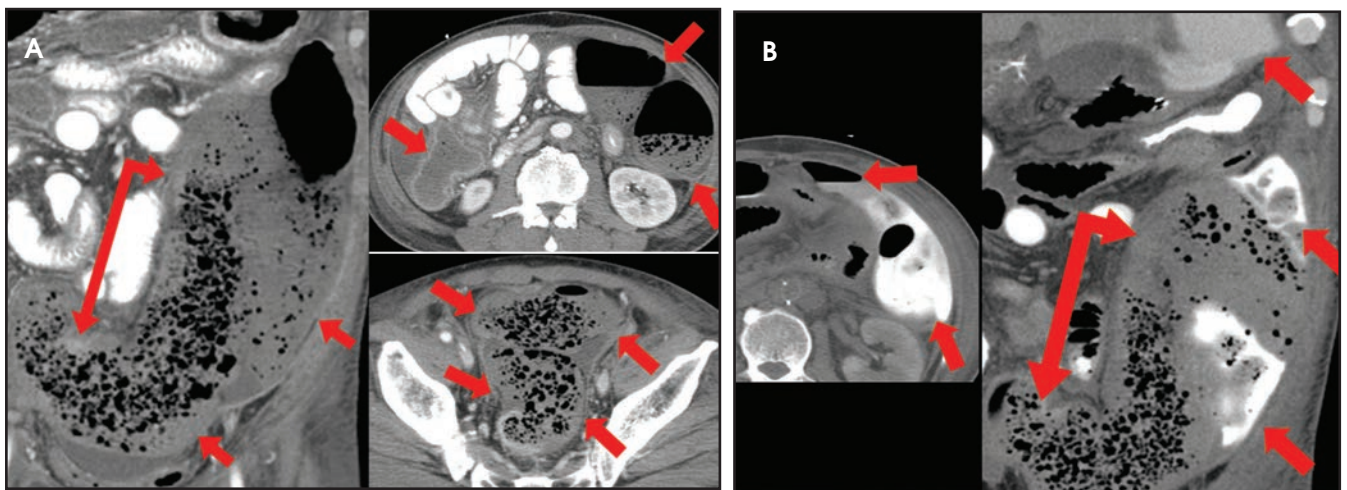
69-year-old, one week post-aortobifemoral bypass graft and a lactate level of 5.2. (A) Dilated, featureless left colon with thin imperceptible wall and differential enhancement compared to right colon (arrows). (B) 24 hours later, repeat CT shows perforation with free air (arrow), extraluminal spillage of enteric contrast (arrows), and dilated, featureless left colon with non-enhancing wall (double arrow). Intraoperative findings: severely necrotic descending colon and sigmoid with bowel-wall liquefaction and area of abnormality involving the mid-transverse colon to rectum.
